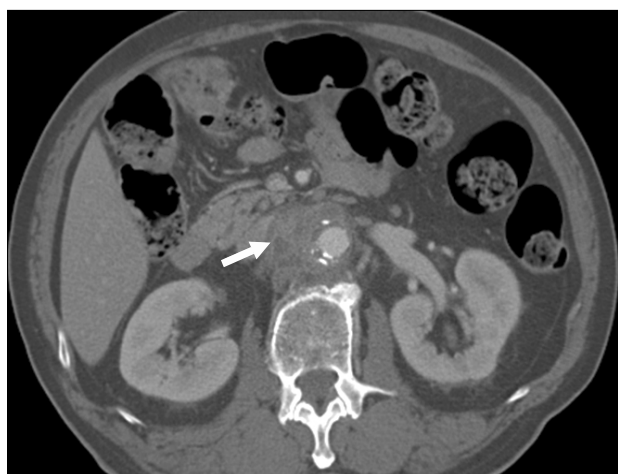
Abdominal computed tomography scan showing soft tissue infiltration and ischemic lesions around the aorta (arrow).
